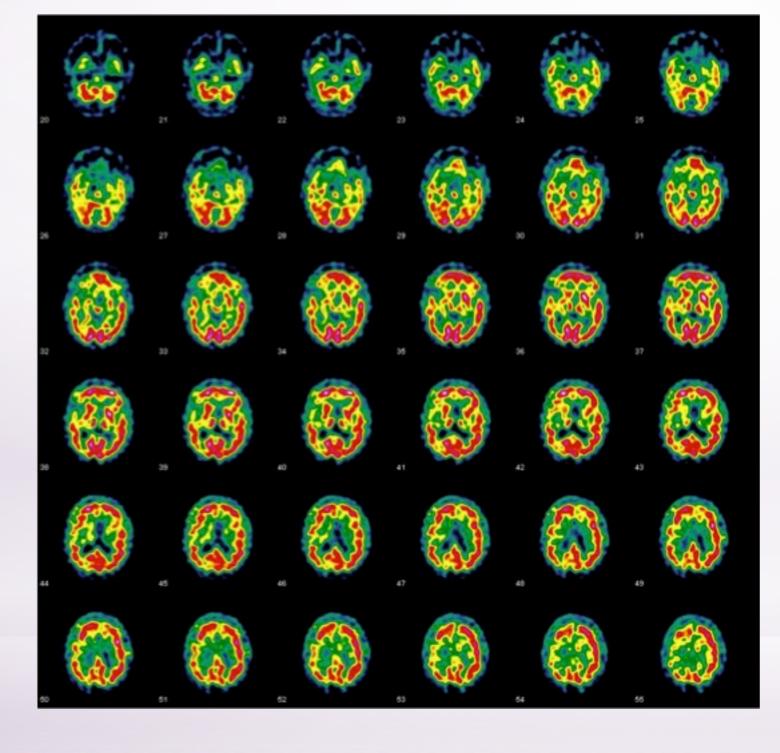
SPECT: non-homogeneous hypoperfusion on the temporal and parietal cortex of both sides.
